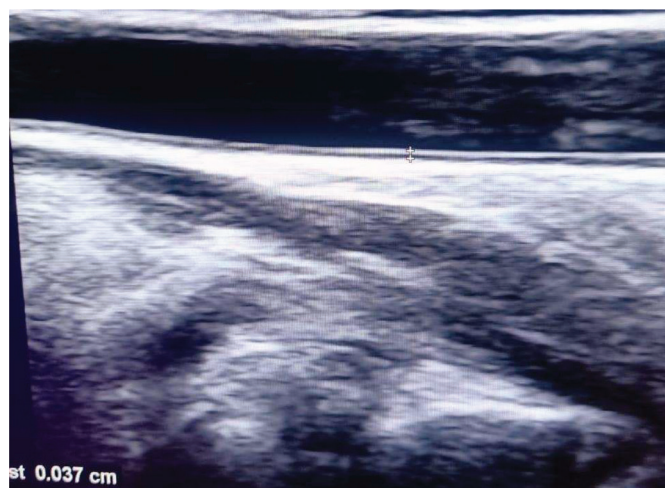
B mode ultrasound of carotid intima-media thickness measurement.
